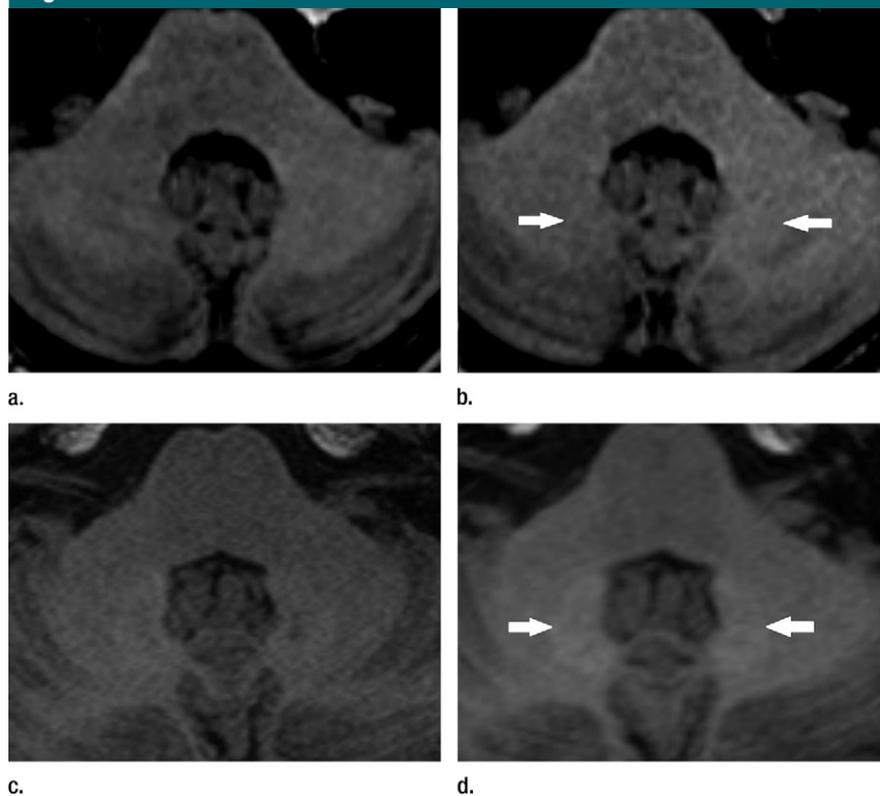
Unenhanced T1-weighted MR images of the typical finding of hyperintensities in the DN (arrows). Images were acquired (a) before and (b) after six administrations of macrocyclic GBCA and (c) before and (d) after six administrations of linear GBCA.
